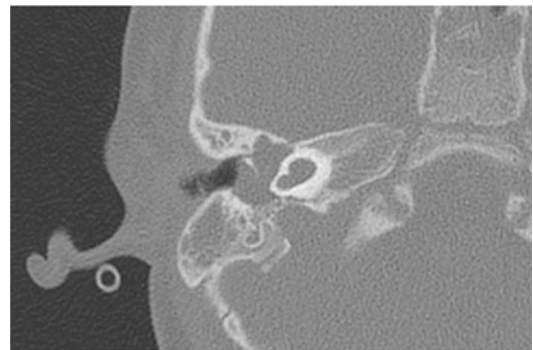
Case 1. HRCT showing an IP-I with fluid filling middle ear and mastoid on the right side
